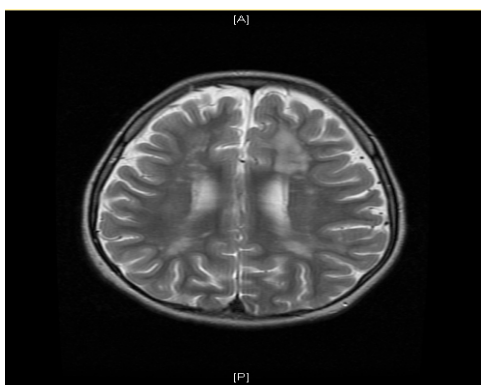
(b): MRI of the Brain T2 Sequence Axial View Showing Hyperintensities in the Cerebral White Matter
